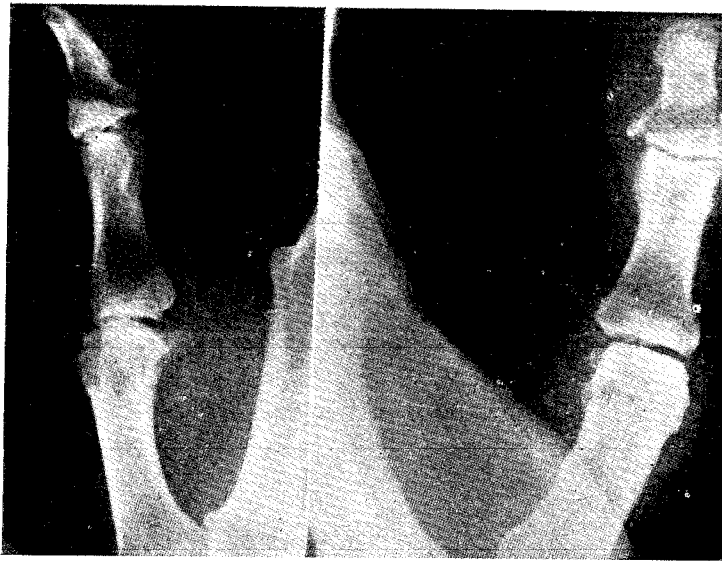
X-ray showing fracture near T.P. joint
